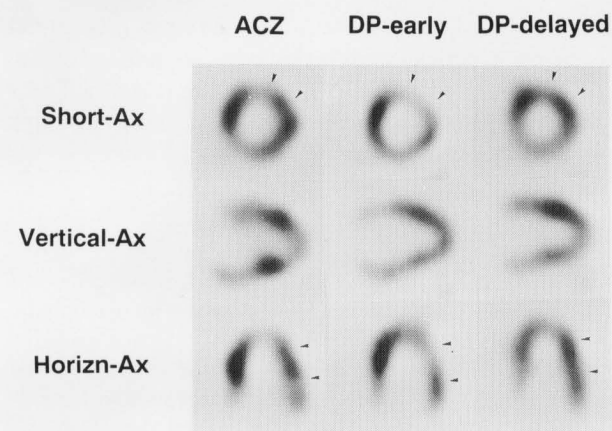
Myocardial SPECT images of Patient 6 with three-vessel disease. Thallium-201 myocardial SPECT with acetazolamide, early and delayed dipyridamole-Tl-201 myocardial SPECT images were showed in the left, middle and right column, respectively. Thallium-201 SPECT with acetazolamide revealed defects in the anterior, anterolateral (arrowheads) and inferior walls. DP-Tl SPECT images demonstrated incompletely reversible perfusion defects in the anterior and anterolateral walls (arrowheads) and showed fixed perfusion defect in the inferior wall. (Horizn-Ax: horizontal axis, Short-Ax: short axis, Vertical-Ax: vertical long axis, other abbreviations as in Fig. 3.)
